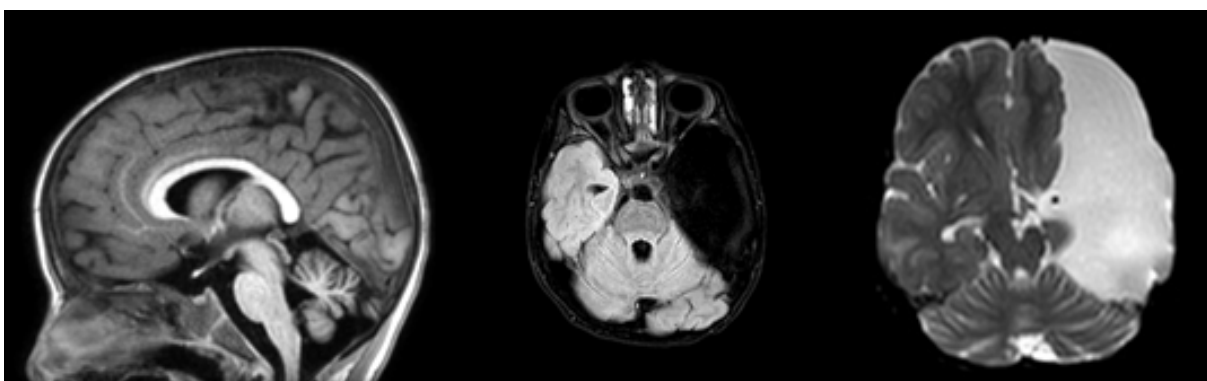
Sagittal FLAIR MR Image showing cerebellar atrophy (Left). Axial FLAIR MR Image showing a large suprasellar cystic lesion (arachnoid cyst) in left temporal region without mass effect (Middle). Axial T2 MR Image showing the same large arachnoid cyst (Right)
